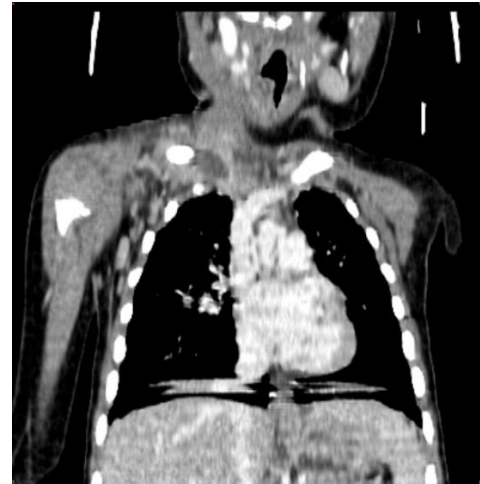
Thoracic CT scan in coronal section depicting a hypodense juxta-osseous collection extending along the inner two-thirds and lower surfaces of the right clavicle, with hypodense contents, a thin wall enhanced after injection of contrast material, spanning approximately 40 mm, and reaching a maximum thickness of 05 mm posteriorly
